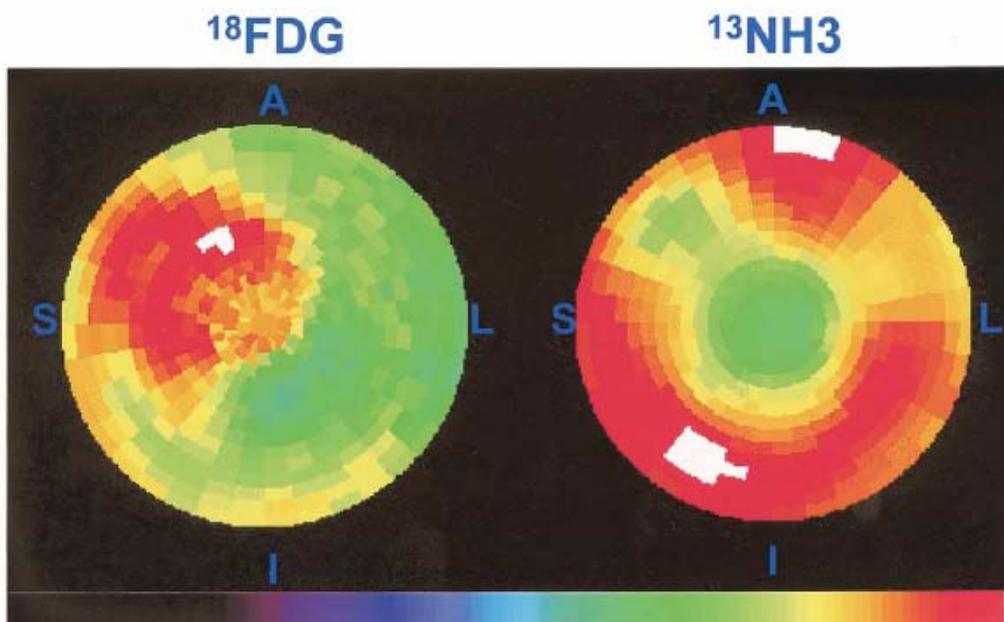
Polar map display of relative myocardial uptake of ^{18}F FDG and ^{13}N -labeled ammonia. S = Septum, I = inferior, L = lateral, A = anterior. Sectors with brighter colors represent higher uptake values. The perfusion deficit (right panel, anteroseptal) corresponds to an area with increased ^{18}F FDG-uptake.
